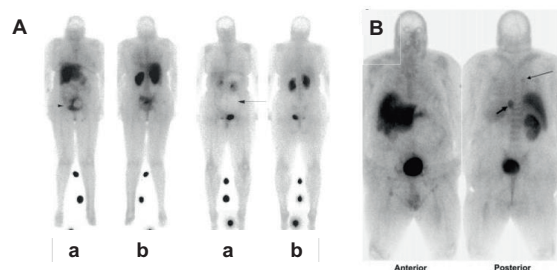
(A) Planar scintigrams of patients at 4 h p.i. of  $[^{111}\text{In}]\text{In-4}$  (183 MBq) (a: anterior, b: posterior). Reprinted with permission from [141]. Copyright 2022 SNMMI, (B) SPECT images of 57-year-old man with pulmonary metastases from renal cell carcinoma at 1–2 h p.i. of  $[^{99m}\text{Tc}]\text{Tc-23}$  (555 MBq). Reprinted with permission from [142]. Copyright 2022 SNMMI.
